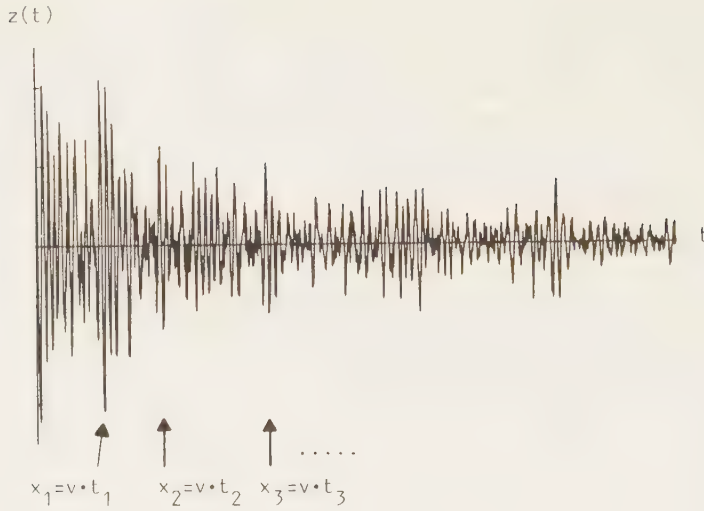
A typical in vivo ultrasonic reflected signal from liver tissue using a 13 mm, 2.5 MHz transducer.
